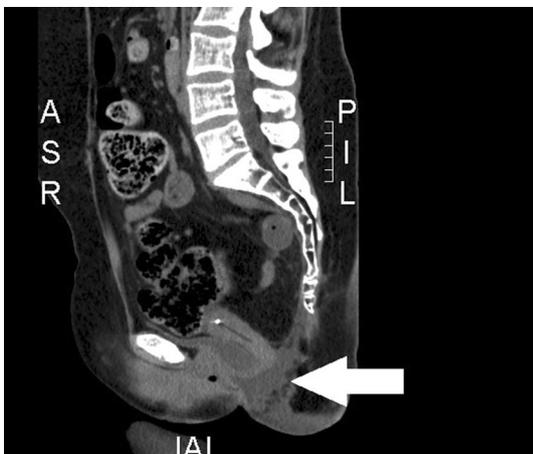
Postoperative CT view with seroma (arrow)
